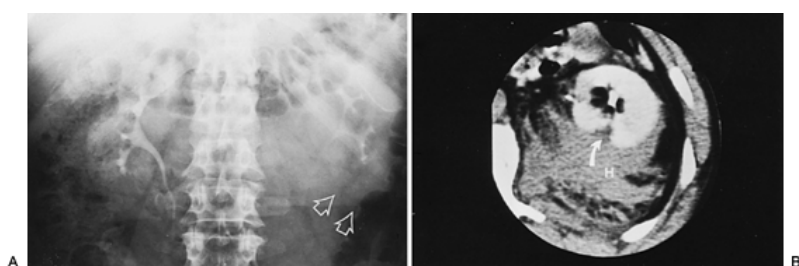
5. Excretory urogram in a young man with abdominal pain and gross hematuria after blunt trauma reveals poor visualization of the lower pole of the left kidney and lateral deviation (*arrows*). B: Computed tomography scan shows retroperitoneal hematoma (*H*) and a minor laceration of the renal parenchyma (*arrow*). Nonoperative management was successful.
